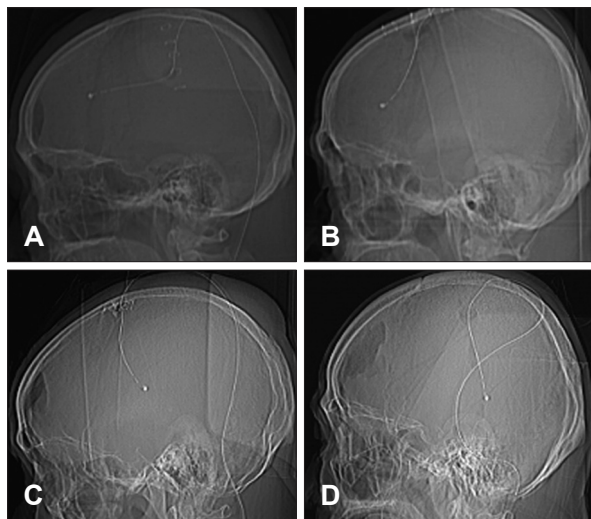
Skull radiographs showing catheter tip position after BHT. The location was classified into two areas: frontal area (A, B) and temporoparietal area (C, D). BHT: burr hole trephination.
